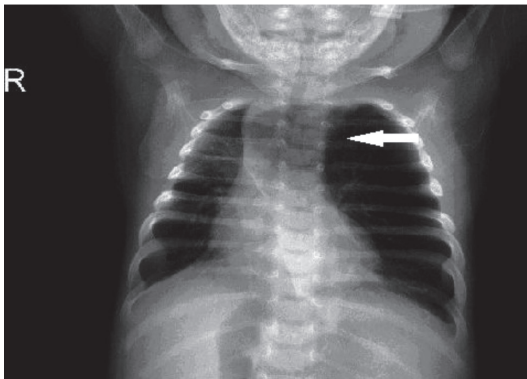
Preoperative chest x-ray showed increased aeration in the left lobe and mediastinal shift to the right
